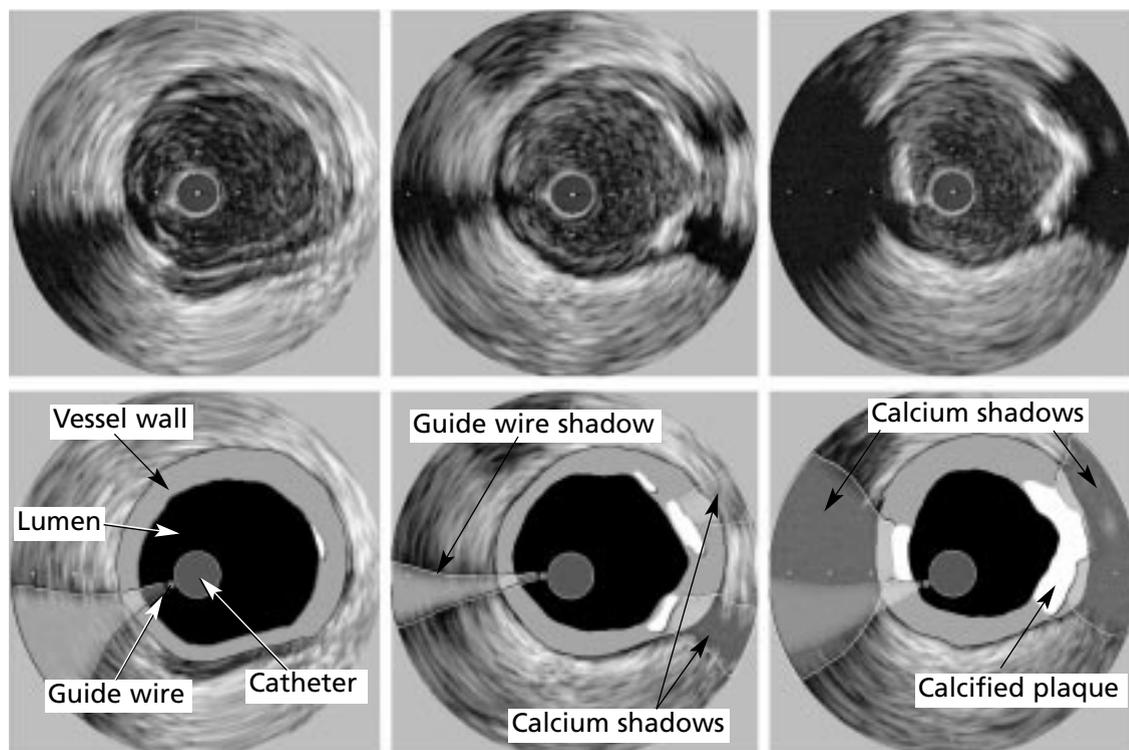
Intravascular ultrasound images of a mildly stenotic plaque with calcification. Three adjacent images of the same lesion are shown.
